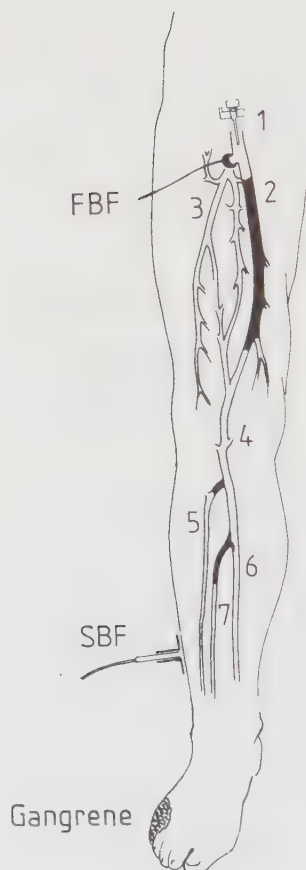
Measurements of femoral artery blood flow (FBF) and of variations in skin blood flow (SBF) with help of an electromagnetic blood flowmeter and a laser doppler flowmeter, respectively.
